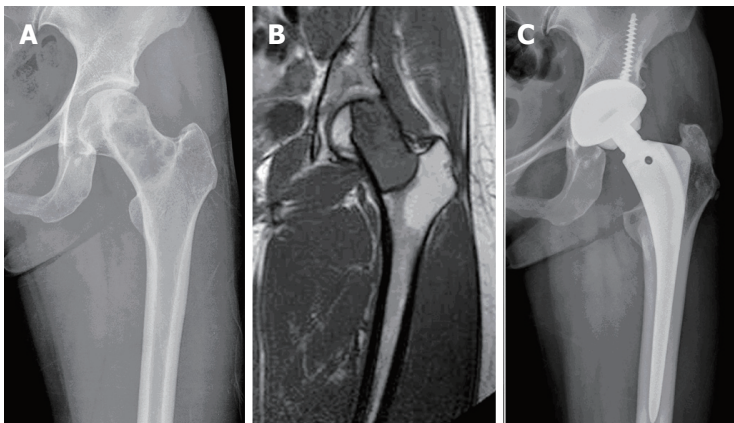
Radiographs of patient 1. A: Radiograph of a 36-year-old woman shows an osteolytic lesion confined to femoral head and neck; B: Preoperative magnetic resonance imaging shows a low signal intensity lesion with well-defined surrounding rim; C: Postoperative radiograph at 6 years after total hip arthroplasty with extensive excision at the intertrochanteric level shows no evidence of local recurrence and implant loosening or osteolysis.
